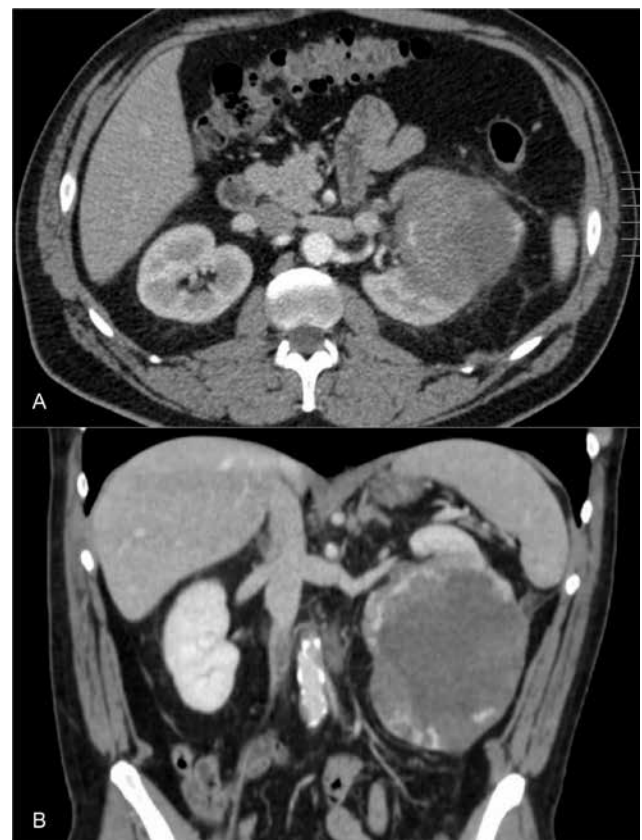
Preoperative computed tomography (ct) scan (a: axial reconstruction; b: coronal reconstruction) showing a mass with a poor vascularization and a collapsed area in the lower pole of the left kidney.
